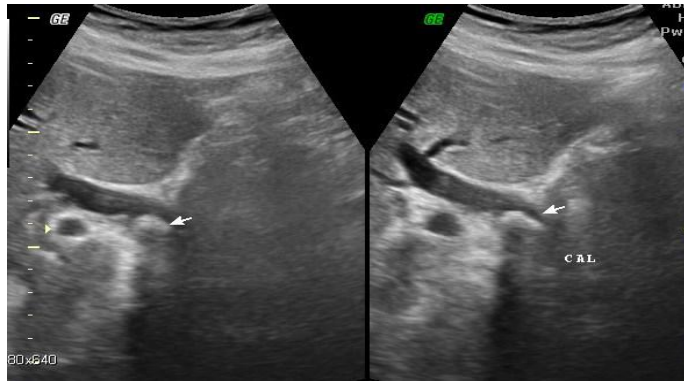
Ultrasound shows a calculus in Distal CBD seen as Echogenic Focus with posterior acoustic shadowing with ppstream dilatation of CBD
